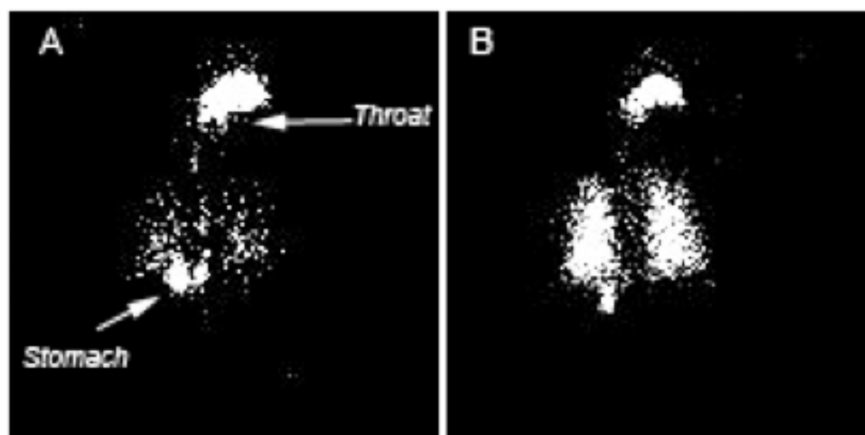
$^{99m}\text{Tc}$  planar scintigraphy depicting the deposition pattern of the radiolabeled drug, albuterol sulfate (ALB), aerosolized from two DPI devices composed of: (A) Handihaler with capsule containing the radiolabeled ALB lactose blend (1%w/w); and (B) Respira technology with pure radiolabeled ALB. Both images were normalized to the same median count.
